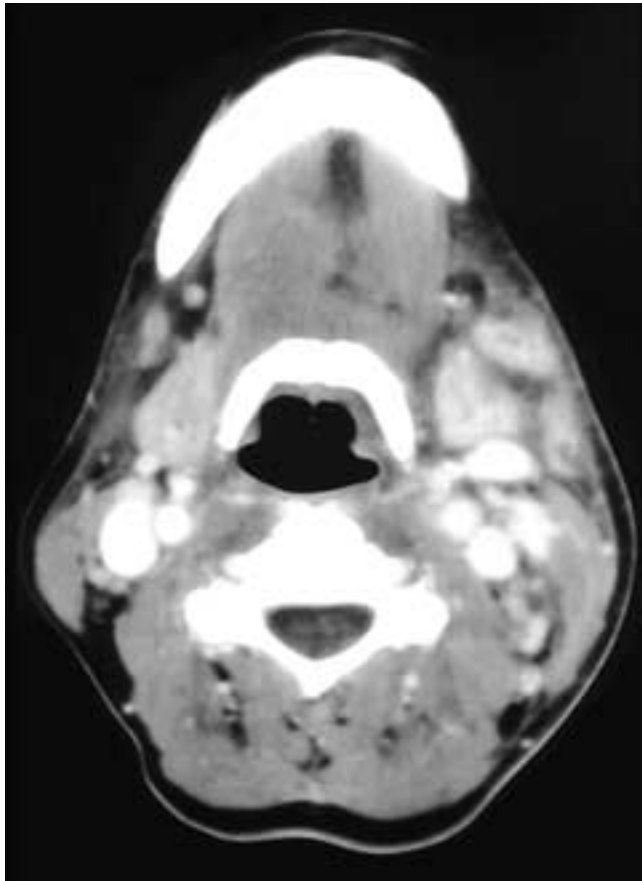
Axial contrast-enhanced CT scans show enhancing left level I and II adenopathy in this patient with herpes zoster affecting the lower left face. There are also findings of local inflammation in the overlying skin and subcutaneous soft tissues.
